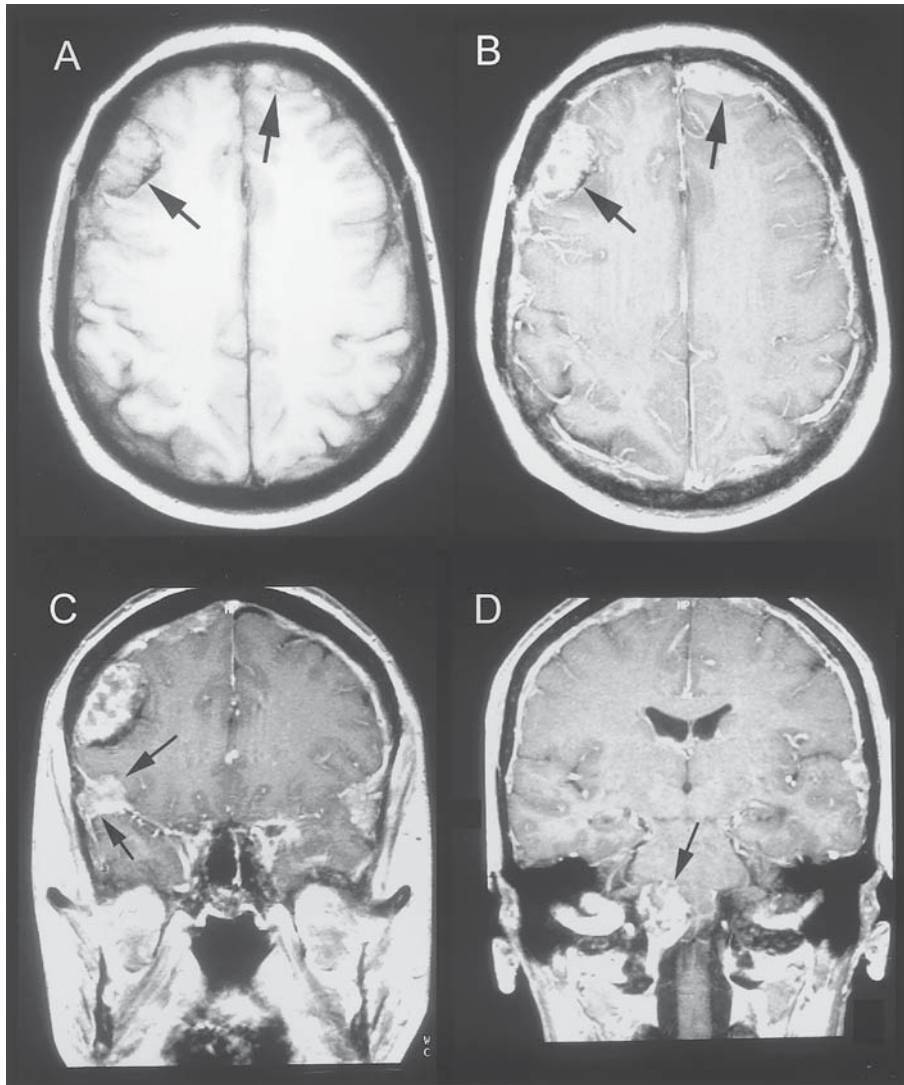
T1 weighted brain MRI performed before (A) and after administration of gadolinium (B–D) on a patient with known metastatic adenocarcinoma of the prostate who presented with diplopia, dysarthria, vertigo, difficulty swallowing, and unsteady gait. Examination revealed bulbar dysarthria, bilateral partial abducens paresis, and right-sided dysfunction of cranial nerves V, VII, IX, XI, and XII with hypalgesia in the distribution of the 2nd and 3rd branch of the trigeminal nerve, diminished nasolabial fold, retraction of the uvula, diminished gag reflex, and protrusion of the tongue to the right. Multiple dural enhancing lesions (arrows) are observed at the convexity (A,B), along the tentorium (C), and compressing the brainstem (D). The latter lesion explained most of the symptoms in the patients. With steroids and radiotherapy, the symptoms disappeared.
